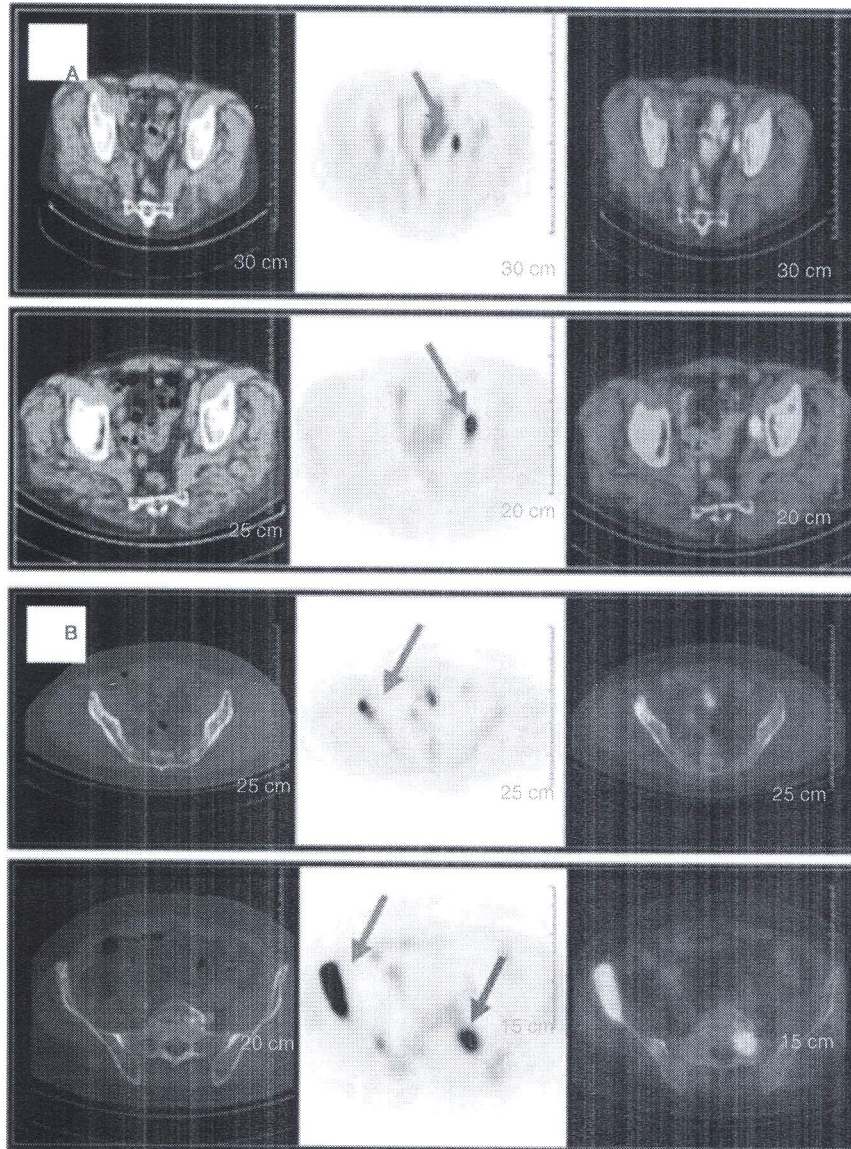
[ $^{18}\text{F}$ ]Fluorocholine positron emission tomography/computed tomography ( $^{18}\text{F}$ FC PET/CT) findings: (A) increased uptake intensity; (B) increased number of pathological  $^{18}\text{F}$ -choline uptake sites.
